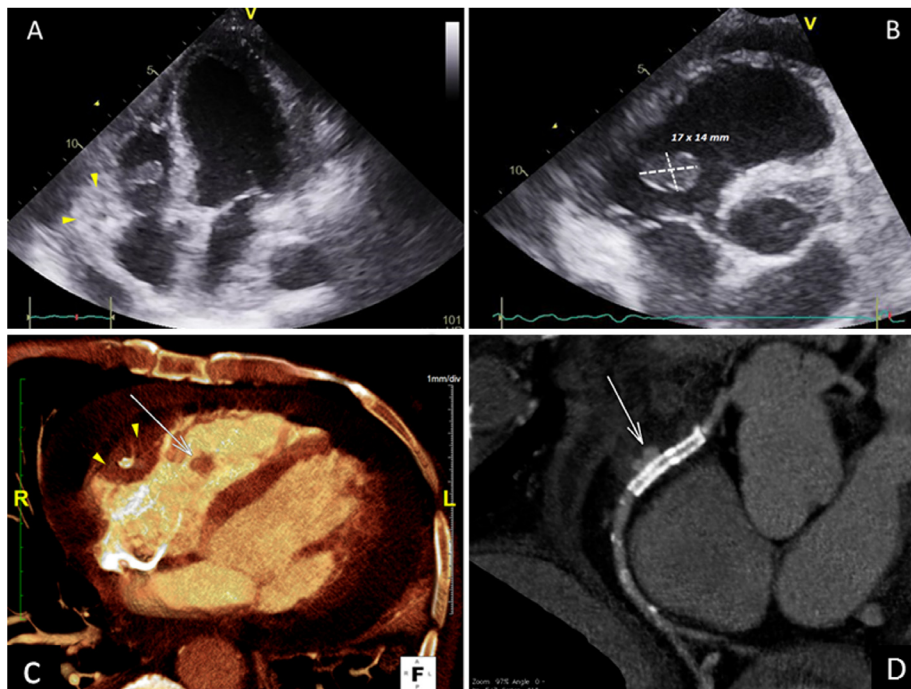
Imaging showing tricuspid valve vegetation (arrow) with hematoma around the right coronary artery (arrowhead) and pericardial effusion in transthoracic echocardiography (A and B) and cardiac computed tomography scan (C). D: computed tomography coronary angiography showing the right coronary artery aneurysm excluded by the overlapping stent.
